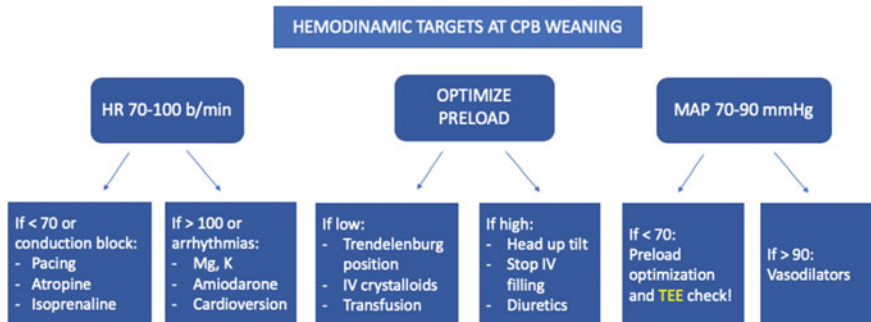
Hemodynamic targets at cardiopulmonary bypass weaning. HR heart rate; MAP mean arterial pressure, Mg magnesium, K potassium, IV intravenous, TEE transesophageal echocardiography
